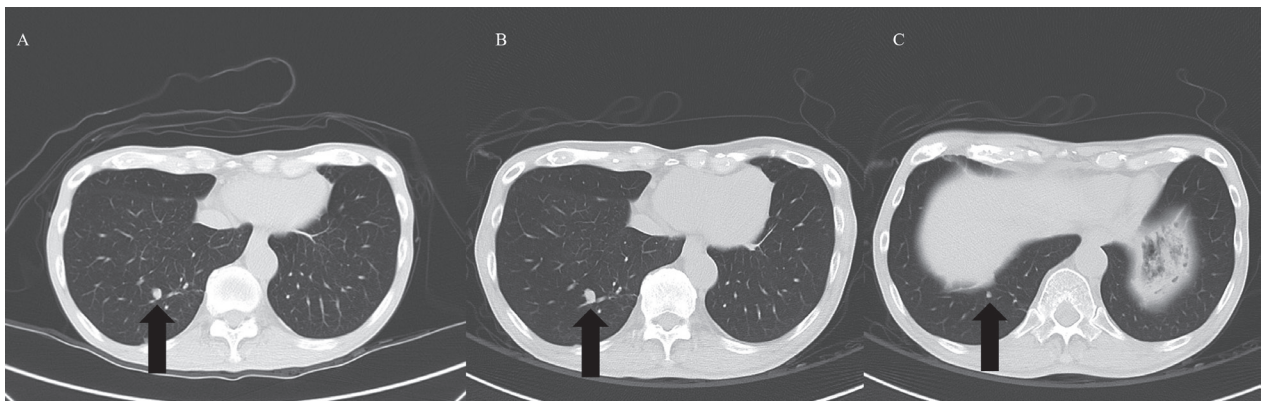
(A) 8-mm nodular lesions at the RLL at the initial presentation (arrow). (B) Slight increase in the size of the previous RLL lesion during follow-up (arrow). (C) Another new pulmonary lesion at the RLL seen in the following chest CT (arrow).
